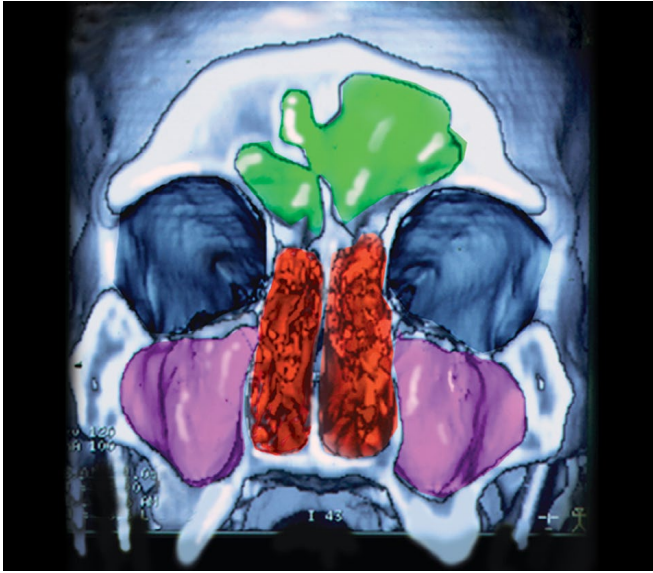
Frontal view of a 3-D computed tomography reconstruction of an adult male human (author SM) showing the topographical relationship between frontal sinus (seen in green) and maxillary sinus (seen in purple) to the nasal cavity proper (seen in red); note the characteristic asymmetry in frontal sinus morphology. The maxillary sinus is the largest of the four paranasal sinuses exhibited by humans and dominates the midfacial architectural space. Sphenoid sinuses are not visible in this coronal plane.
